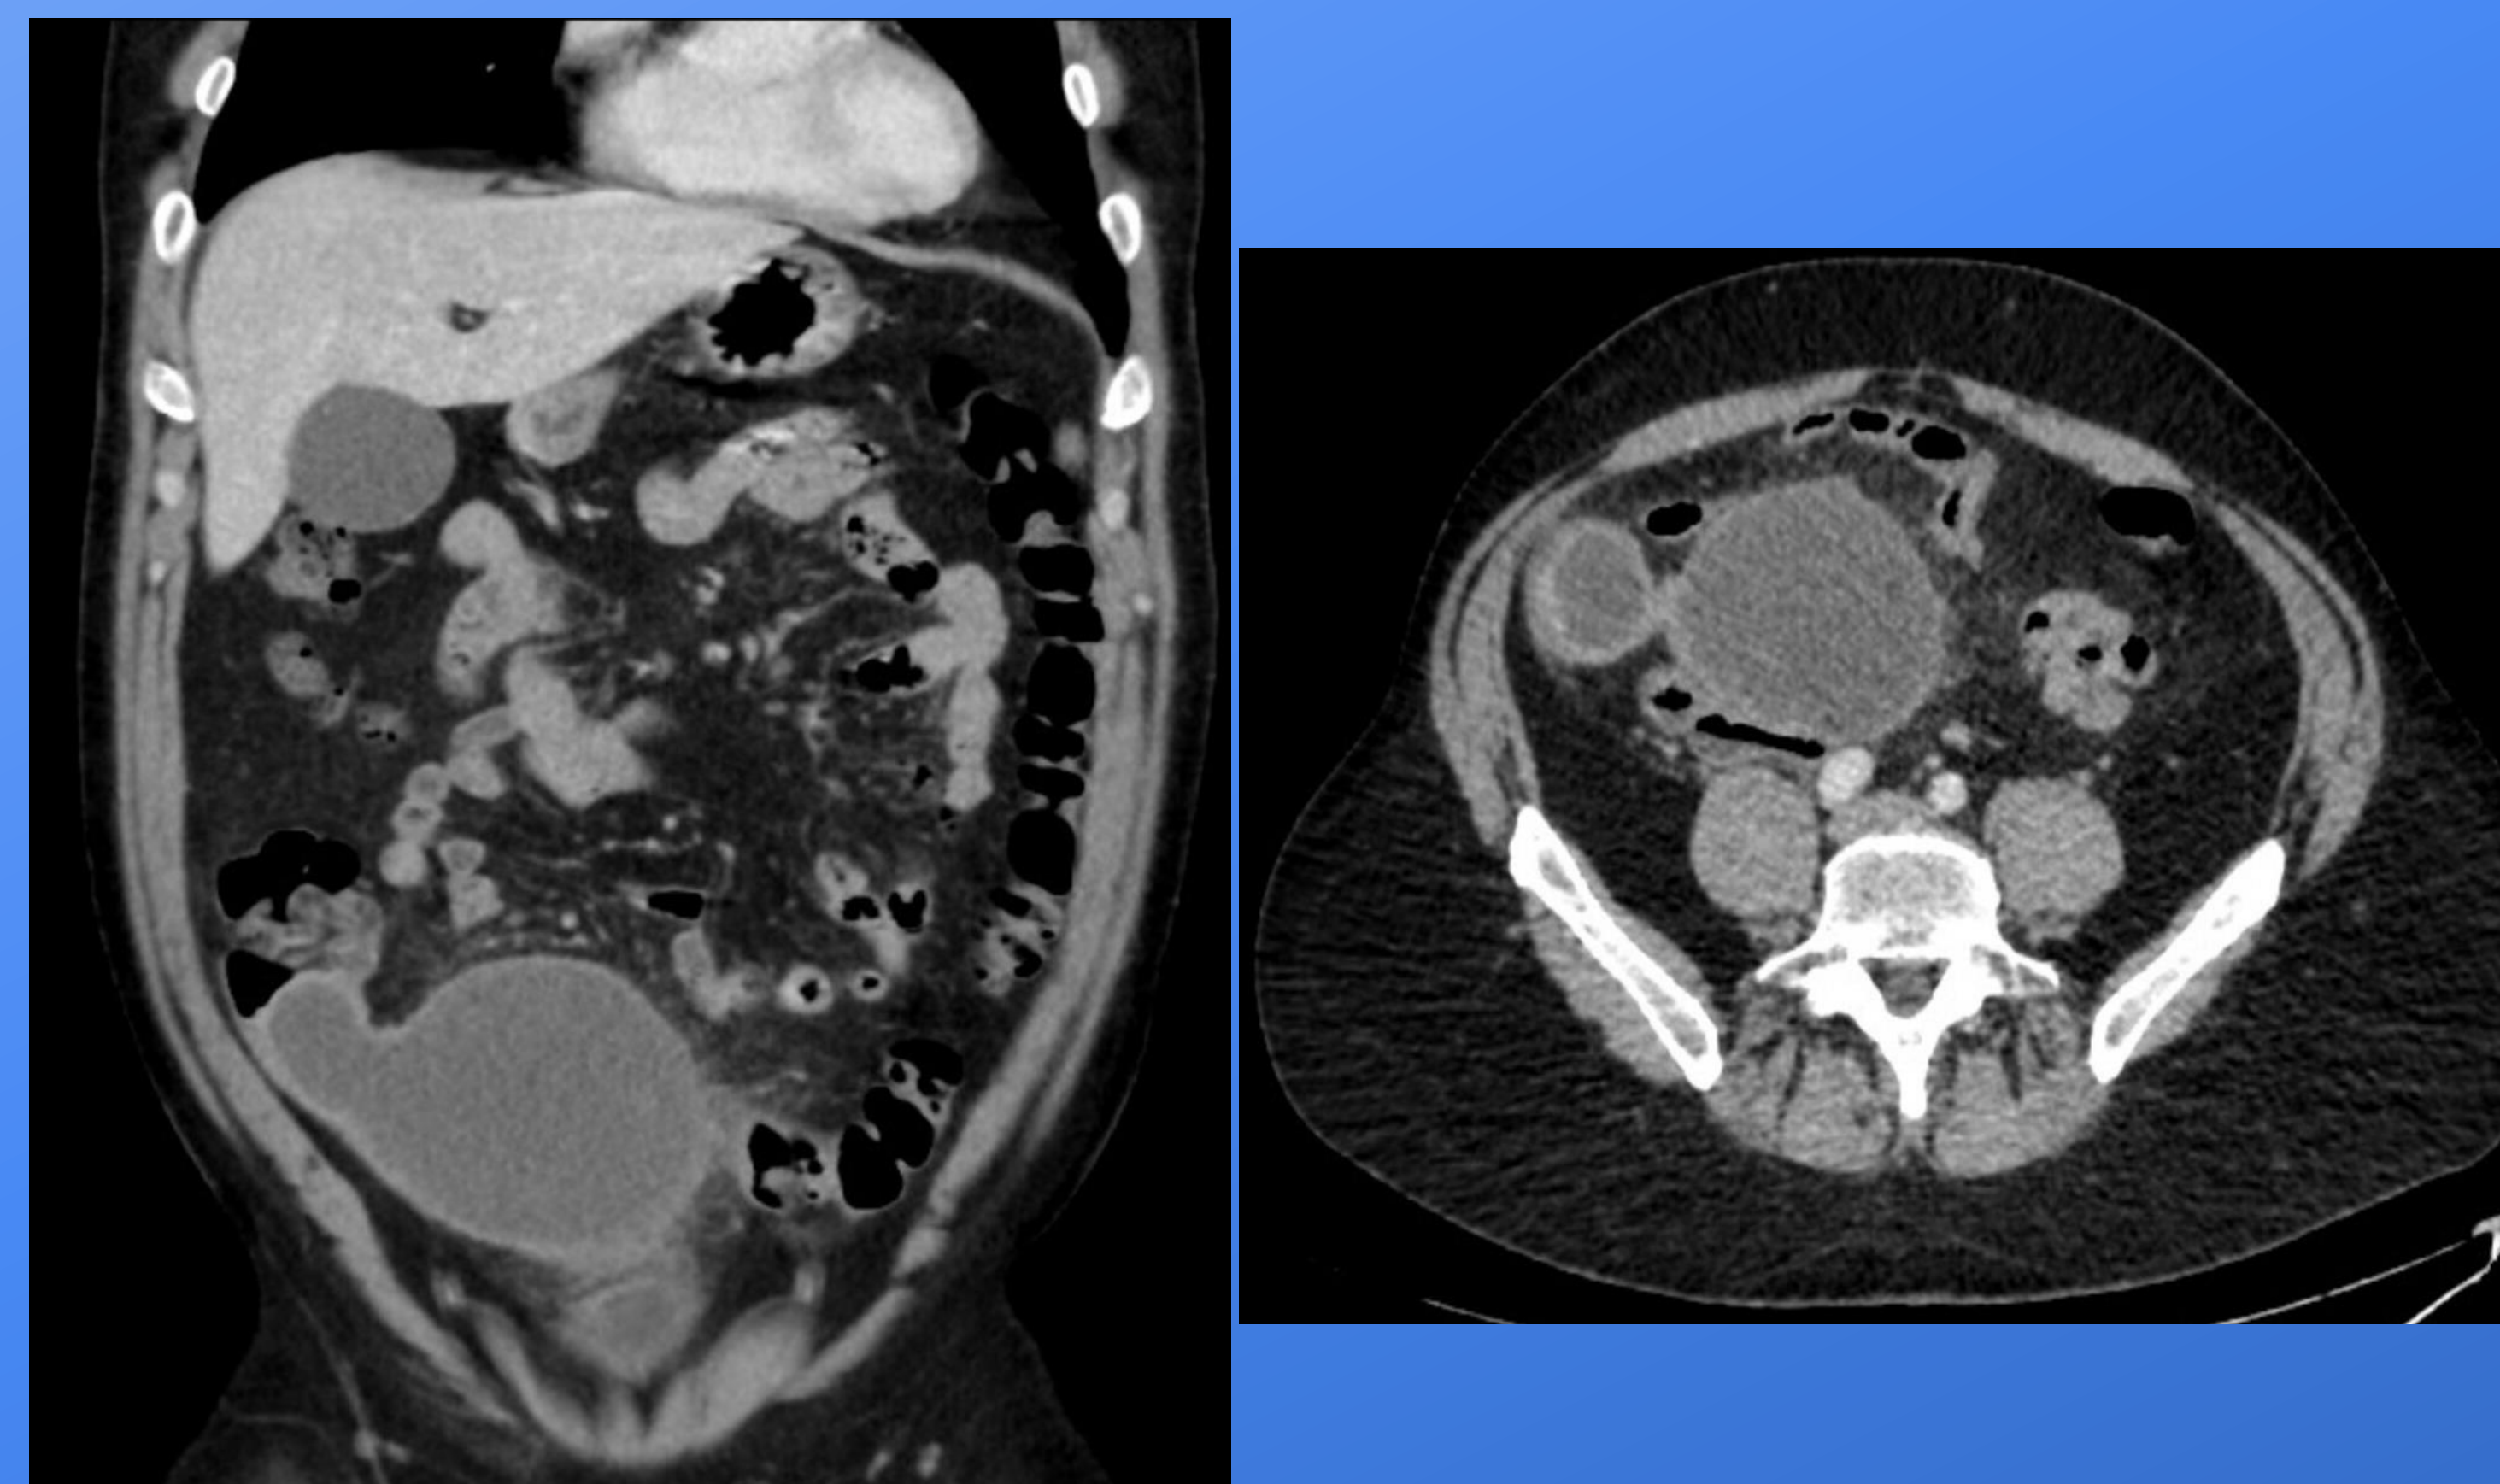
CT AP demonstrating a pear shaped, cystic mass believed to be a distended appendix secondary to appendiceal mucocoele (15x10cm).
